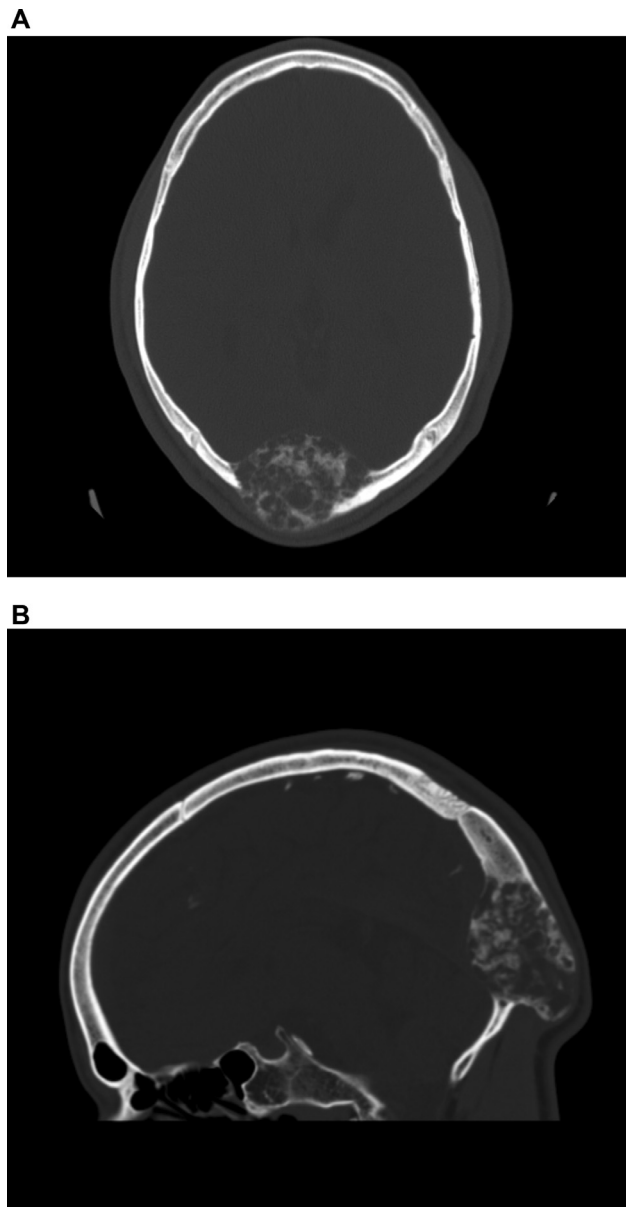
Axial and sagittal head CT in bone window shows an expansile, mixed lytic and sclerotic mass, in the midline occipital bone measuring up to 5.7 cm.
